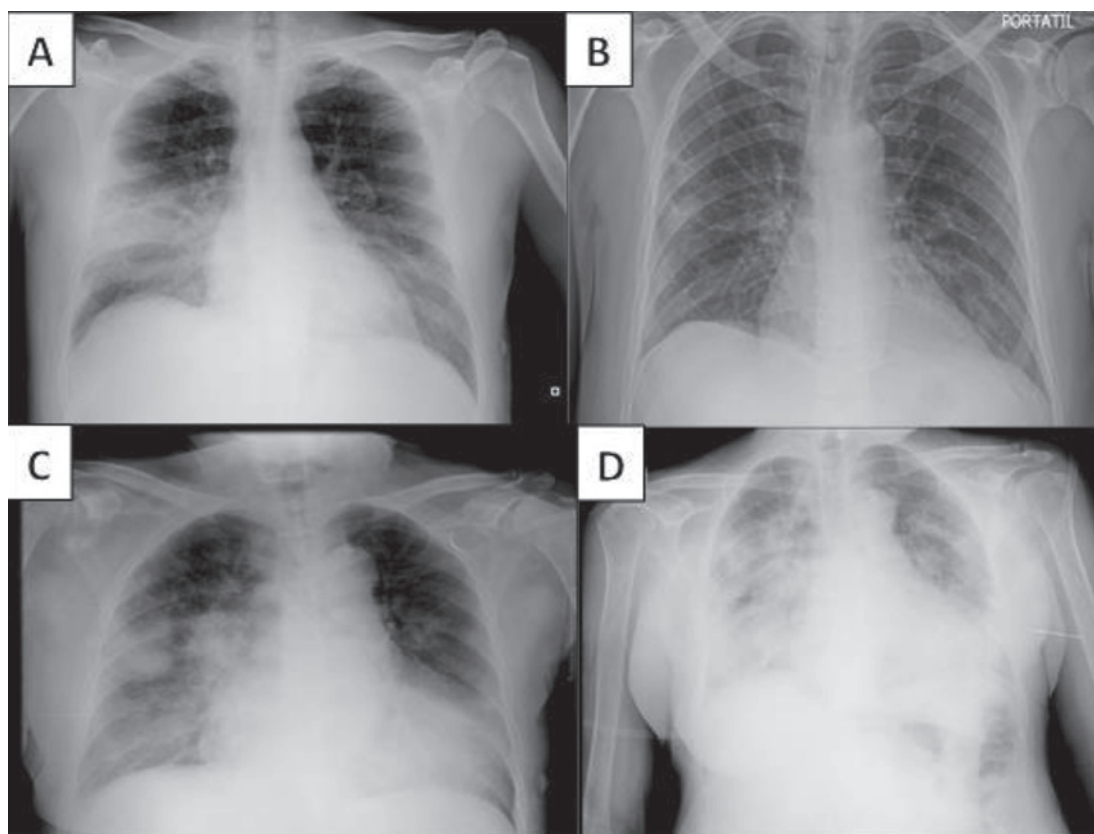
Chest x-rays of two patients with advanced CKD and COVID-19. Patient No. 3 showed bilateral opacities at admission, predominantly in the right lung median lobe (a), which mostly disappeared at discharge (b). Patient No. 4 showed bilateral pneumonia at admission (c), which intensely worsened until the night before death (d).
